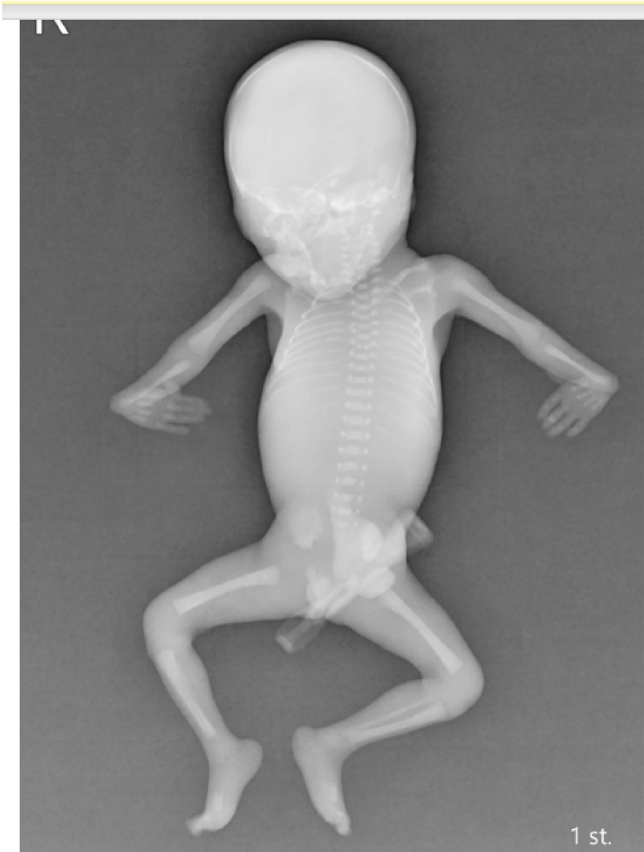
(A) The fetus with bilateral radial dysplasia and (B) the skeletal radiographic finding.
